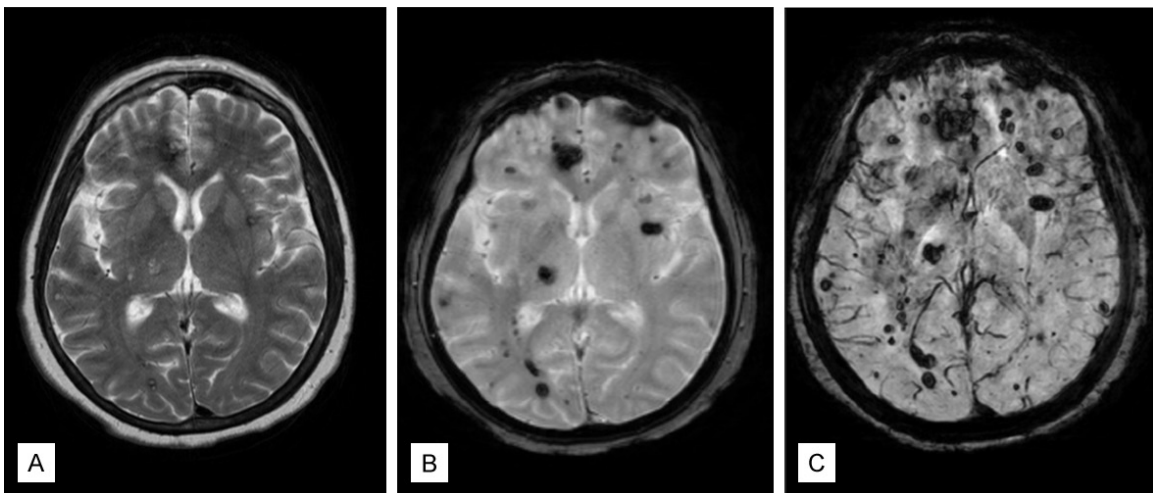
A. Axial T2-weighted image shows three focus of low signal intensity on the right frontal, occipital and left basal ganglia regions. B. T2*-weighted GRE image demonstrates multiple foci of low signal intensity on both cerebral hemisphere regions. C. SWI shows a higher number of lesions and confirms the presence of larger lesions, which are not seen on the T2*-weighted GRE image.
